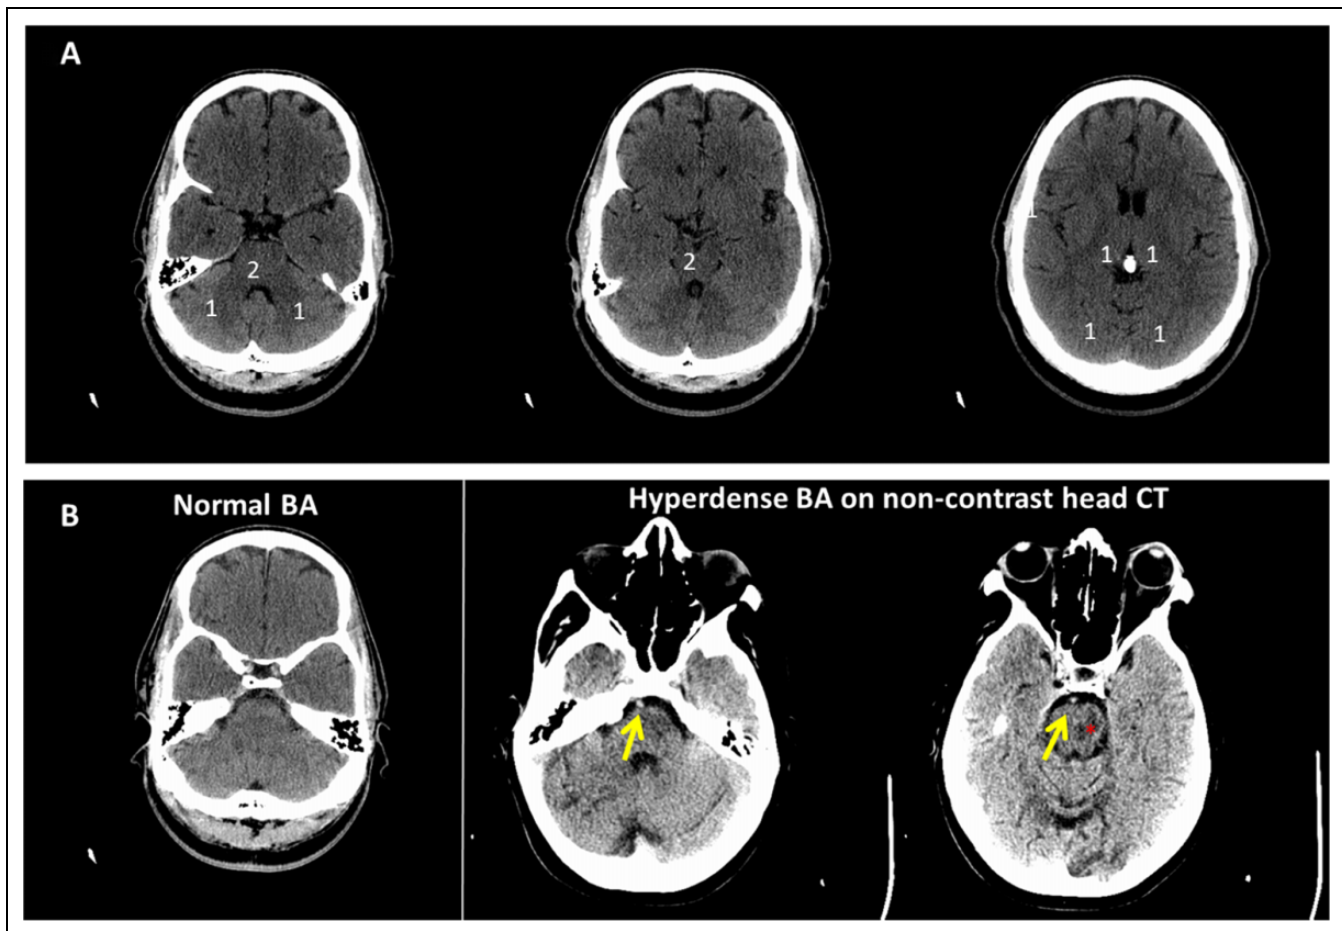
Axial sections through representative noncontrast head CT scans demonstrating: (A) normal head CT with superimposed posterior circulation Acute Stroke Prognosis Early CT (pc-ASPECT) scoring territories. A scan with no hypodensity would receive a score of 10; 1 to 2 points are subtracted for hypodensity in each of the areas represented. One point is subtracted for hypodensity in the right and left cerebellum, thalamus, and occipital lobe and 2 points are subtracted for any hypodensity in the pons or midbrain. B, Left panel demonstrates a normal posterior fossa and normodense basilar artery. The middle and right panels depict a hyperdense basilar artery (arrow). Early ischemic changes in the left midbrain are noted (*). CT indicates computed tomography.
